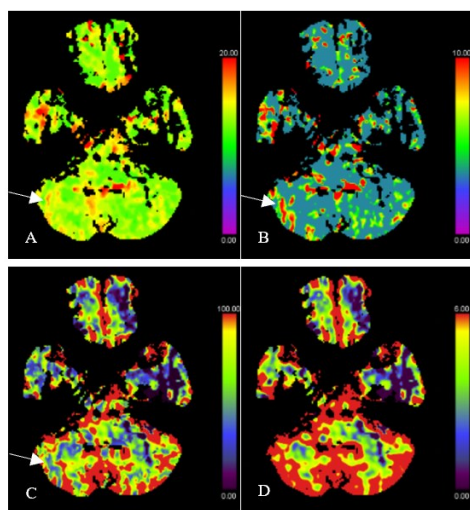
Cerebral CT perfusion, November 1, 2023
